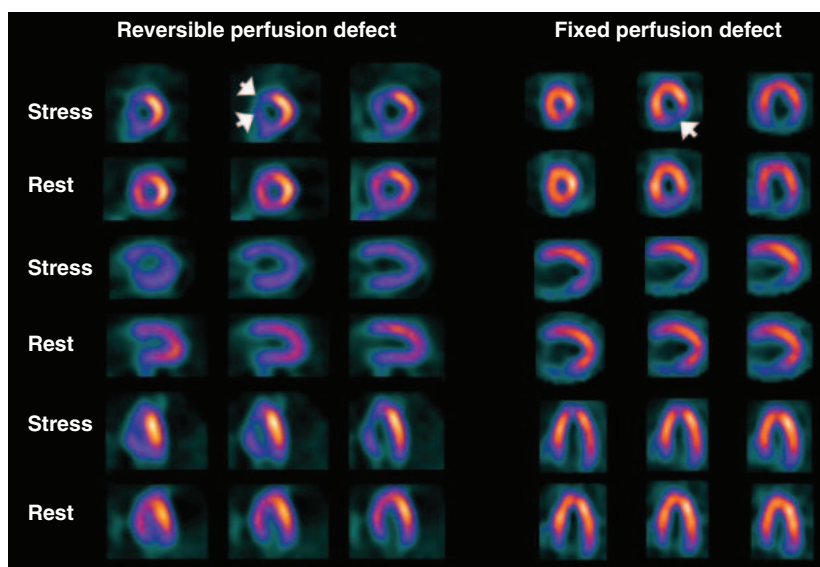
Selected technetium-99m sestamibi myocardial perfusion single-photon emission computed tomography images of two different patients demonstrating a reversible perfusion defect involving the anterior and septal left ventricular wall, reflecting ischemia in the left anterior descending coronary territory (arrows in left panel), and a fixed perfusion defect involving the inferior and inferolateral walls consistent with myocardial scar in the right coronary territory (arrow in right panel).
